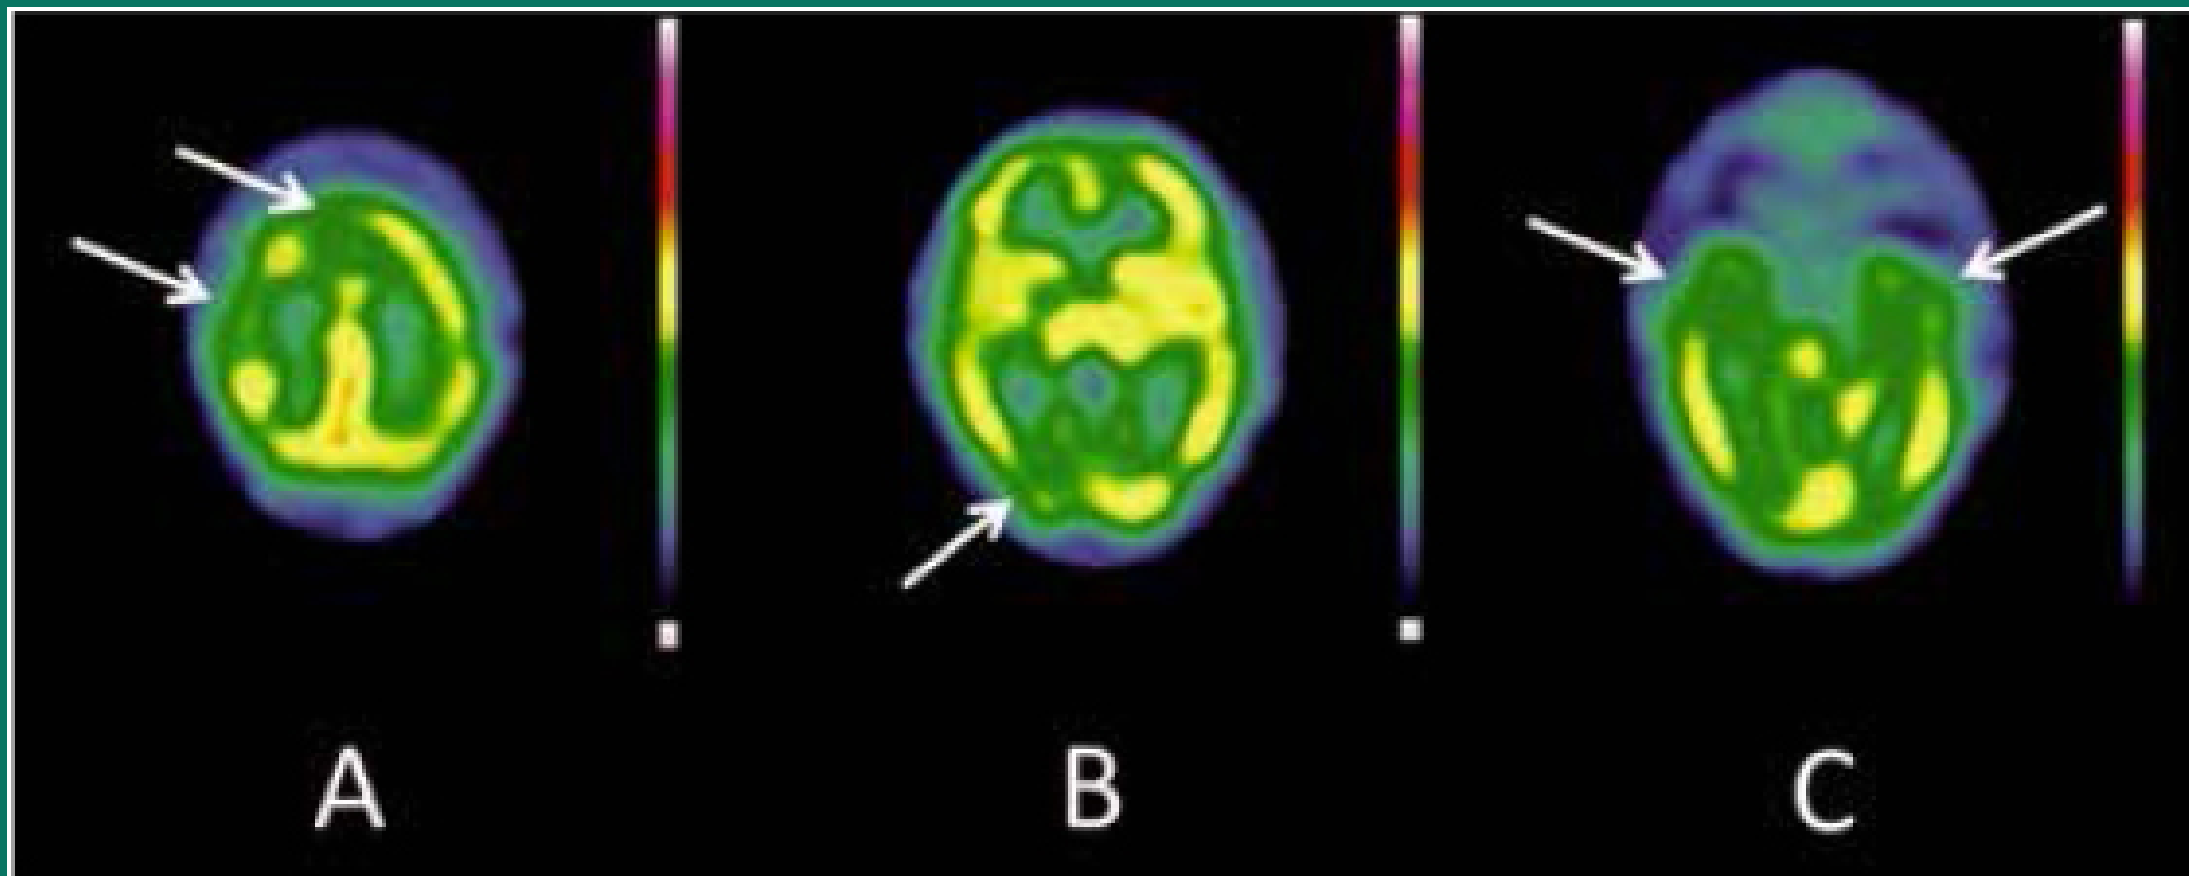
SPECT brain Tc99m (March 2013): A = reduced right frontal and paracingular cortex; B = reduced posterior parietal and right parieto-occipital cortex; C = reduced perfusion bilateral temporal poles.
